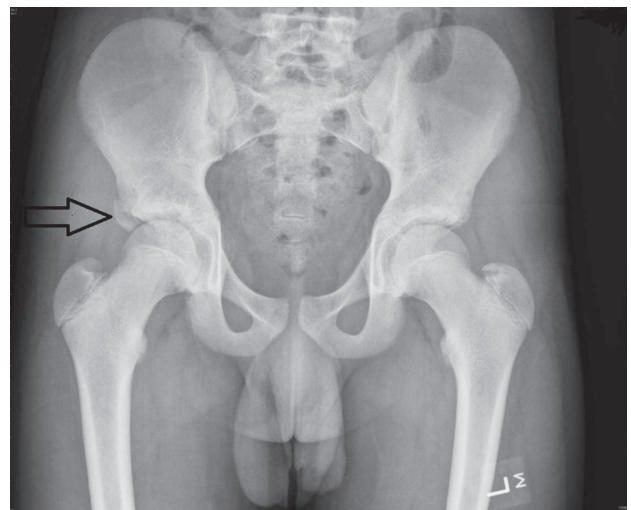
Anteroposterior pelvic radiograph. The avulsed fragment of the lateral aspect of the right acetabulum is identified by the arrow.
